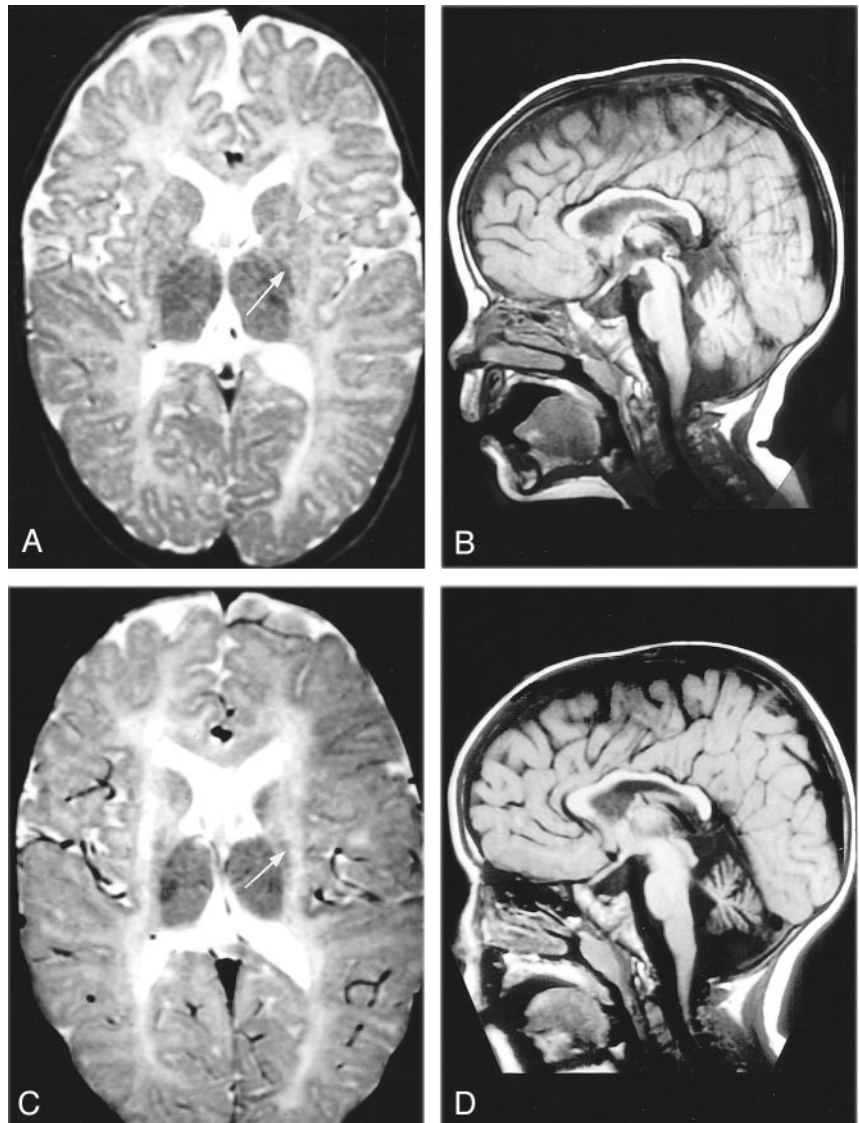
MR images in patient 1, who had disease with intermediate clinical severity.
